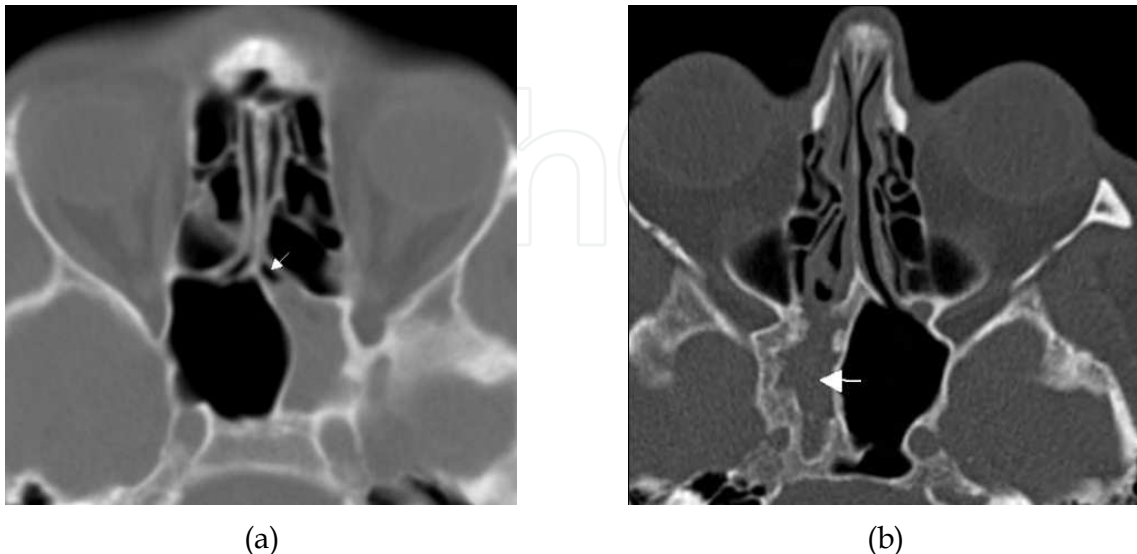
(a) Axial CT shows total opacification of the left sphenoid sinus with slightly thickening of the surrounding bone. Note that the left SER (arrow) contains air. This indicates that the obstruction can be at the level of the sphenoid ostium or the opacification can be due to a polyp originating from inside the sphenoid sinus. (b) Axial CT shows sclerotic bone surrounding the total opacified right sphenoid sinus (arrow), indicating a longstanding infection.
